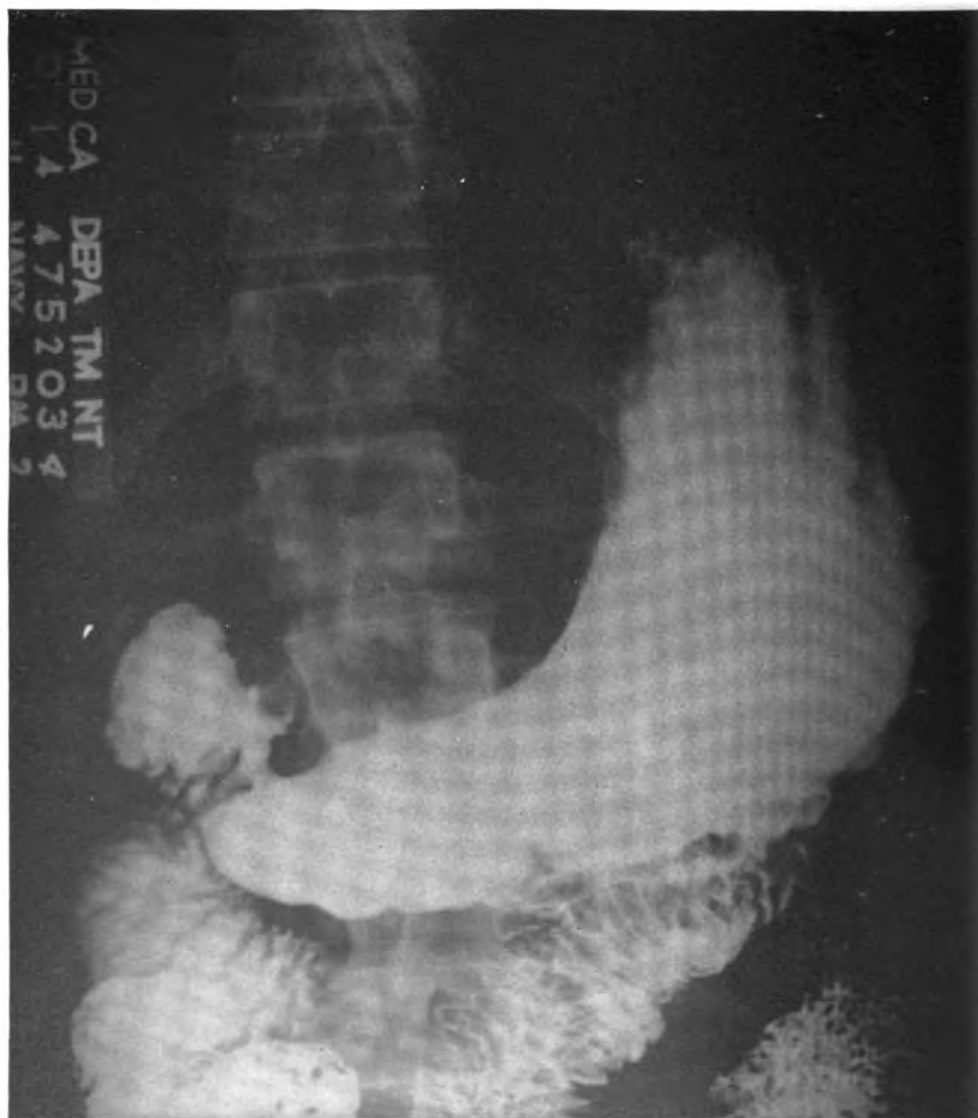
Roentgenogram taken 3 weeks post-operatively shows healing of ulcer although still present. The outline of the duodenum shows marked regression to normal.
